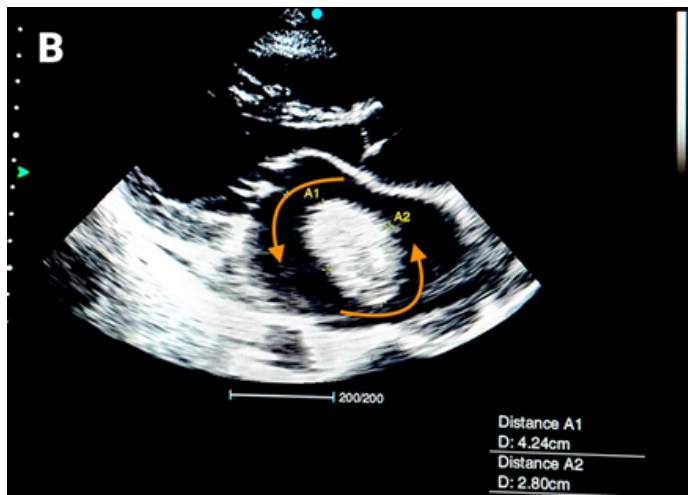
(B) Transthoracic echocardiogram in parasternal long axis view in diastole showed a hockey-stick shape and thickened anterior mitral valve leaflet, a large free-floating ball-valve thrombus (to 4.24 cm in diameter) with anti-clockwise spinning movement in the dilated atrium.
